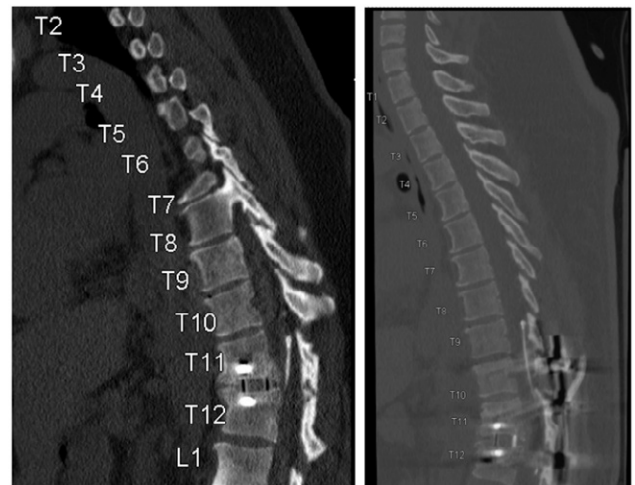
Pre-op vs. Post-op CT scans showing catheter migration
